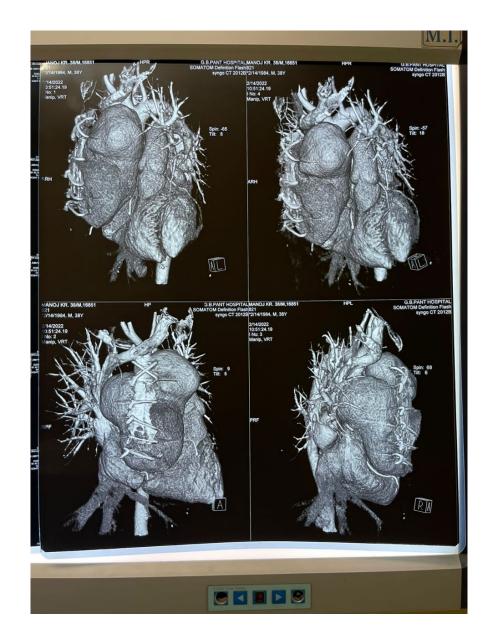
Contrast enhanced CT scan showing the pseudoaneurysm of ascending aorta.
